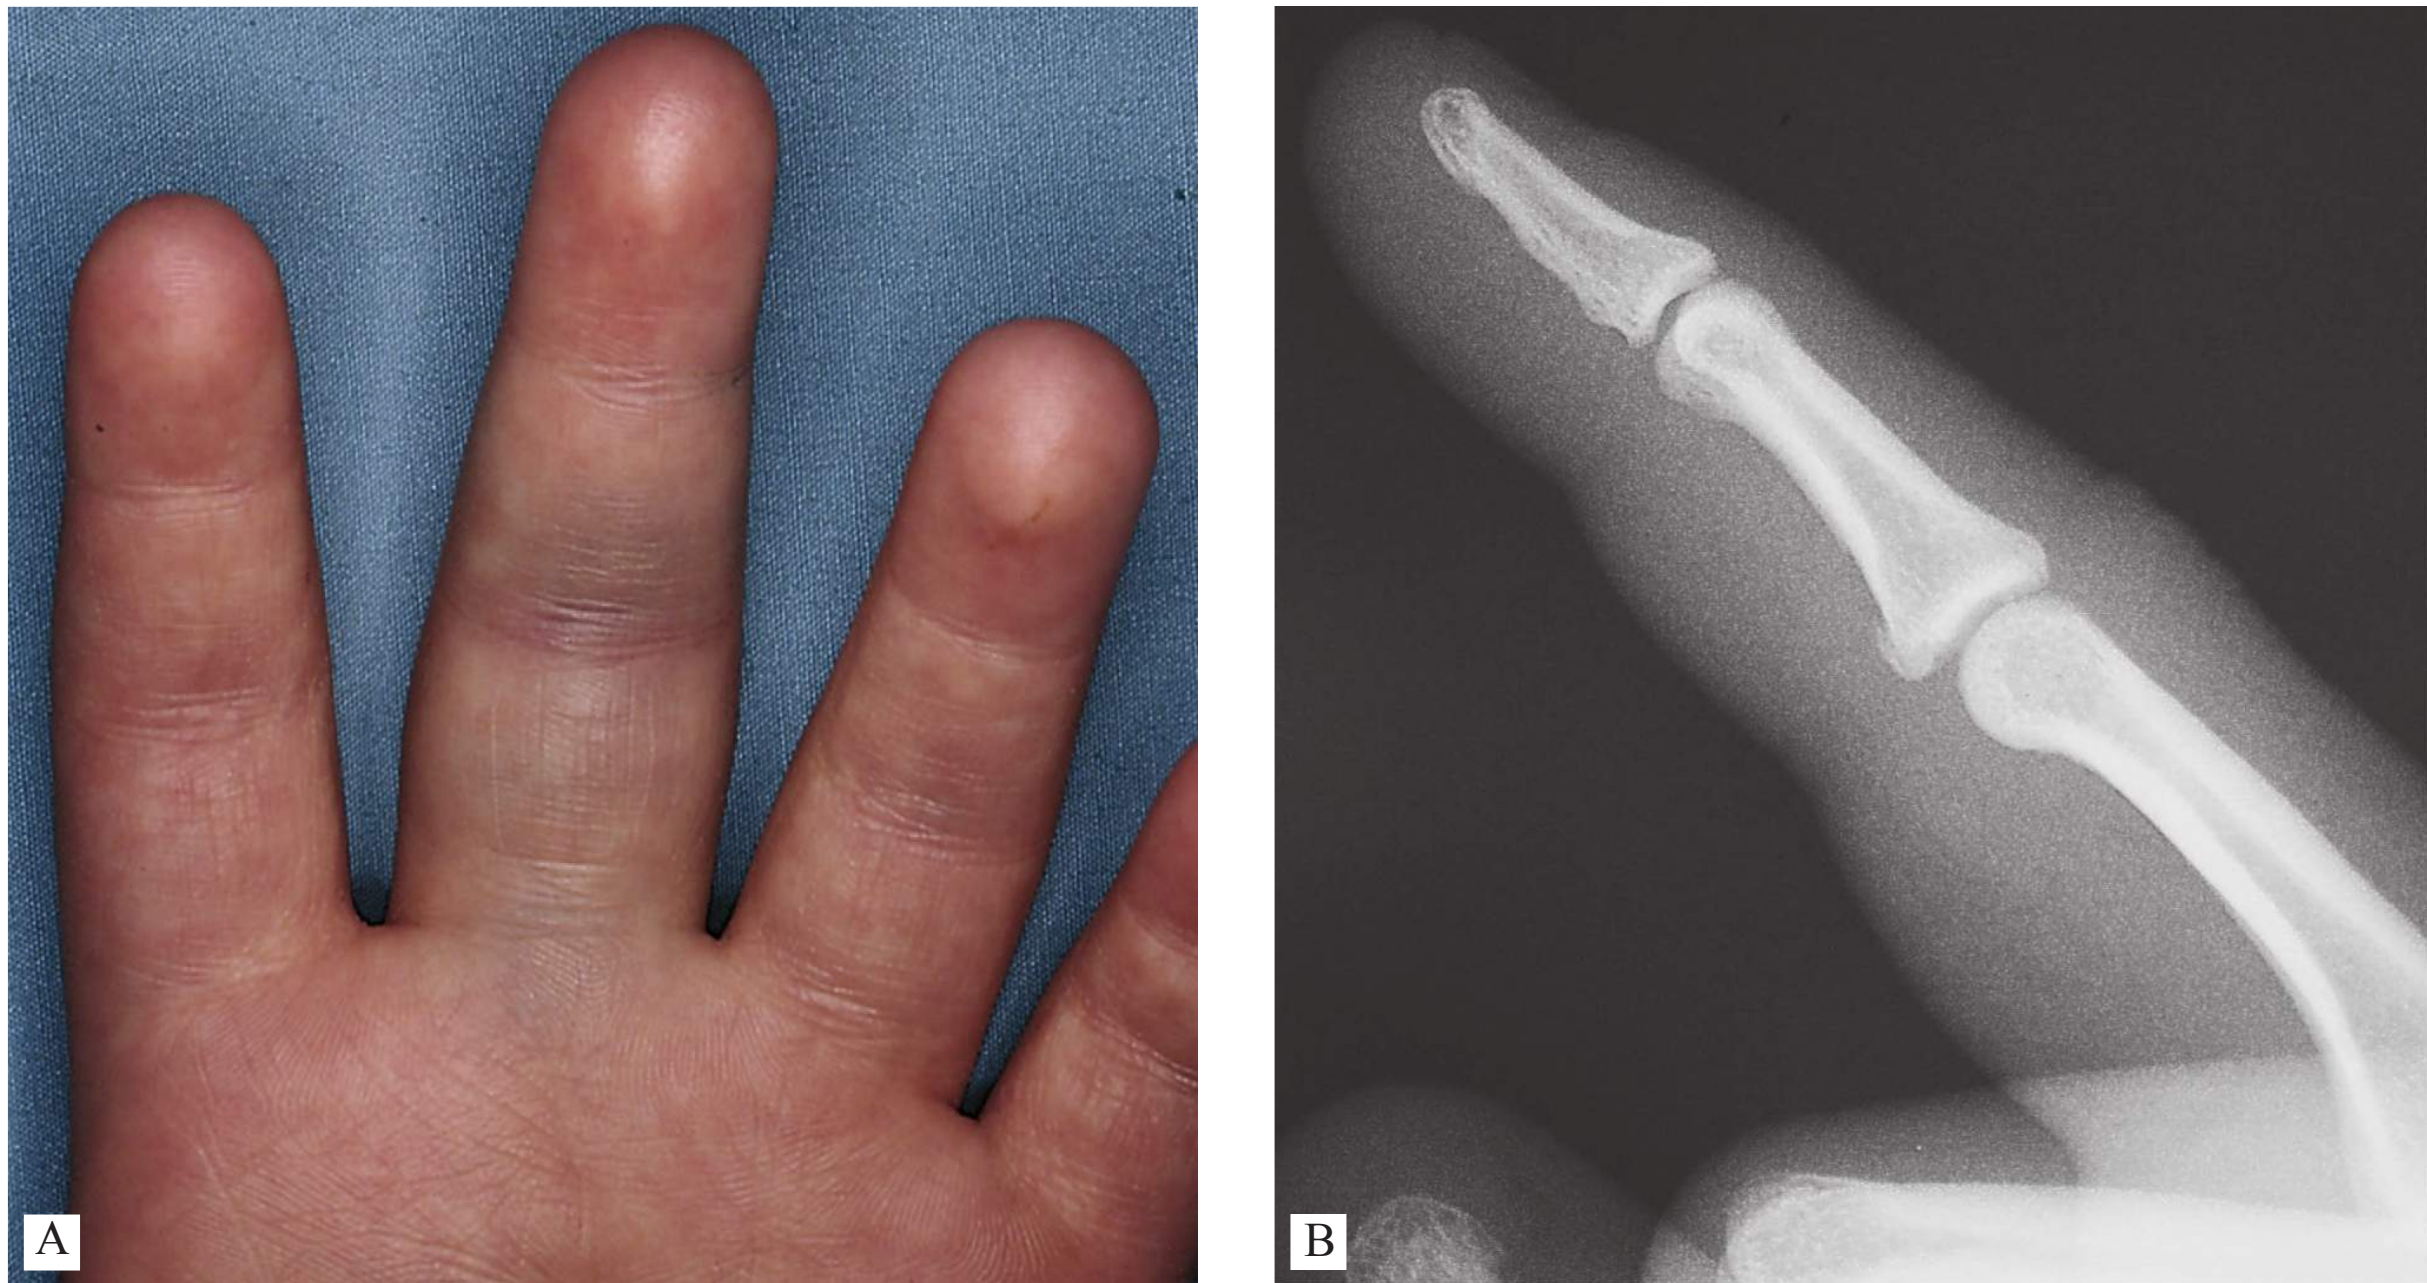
■ Volar Plate Injury. Subtle PIP swelling and ecchymosis of the long digit seen with a volar plate injury (A). Radiographs of volar plate injuries often reveal a small fragment on the volar surface of the PIP joint (B). (Photo contributor: Cathleen M. Vossler, MD.)
